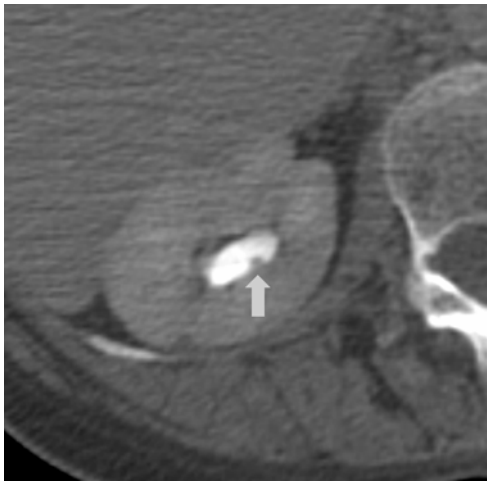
Axial excretory-phase CT urogram. The small impression on the upper pole infundibulum (arrow) was recorded as urothelial tumour.
